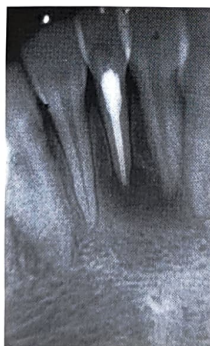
IOPA X-ray showing endodontic treatment in mandibular central incisor and periapical radiolucency extending from # 23 # 26
